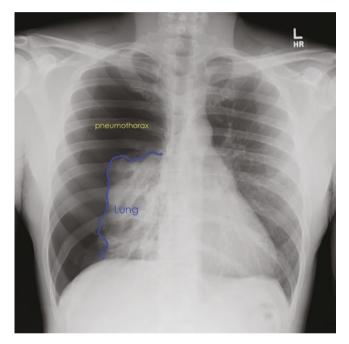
Chest radiograph demonstrating 90% collapse of the right lung
